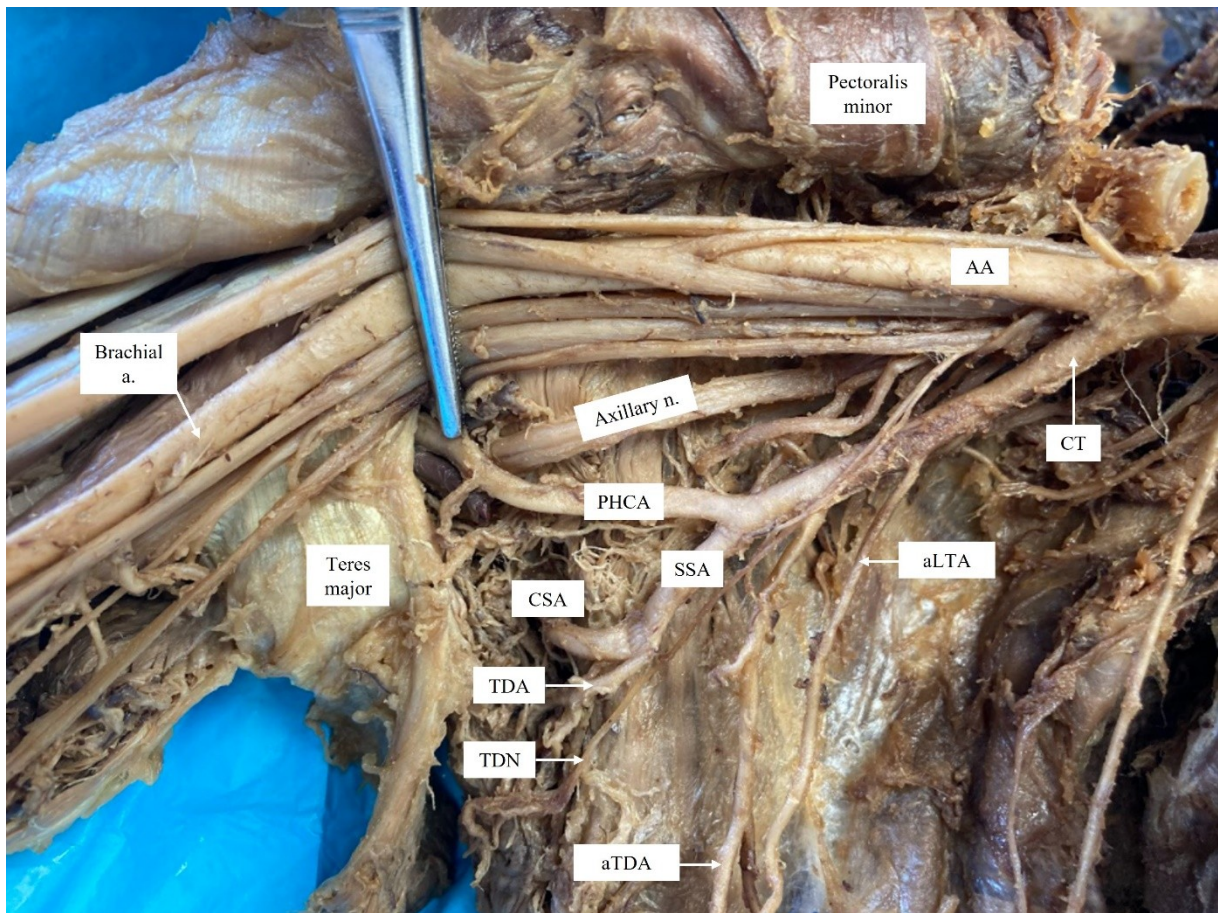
Common trunk from the first part of the AA. The CT provides the aLTA and aTDA before terminating as the SA (which bifurcates into the CSA and TDA) and the PHCA artery. The TDA travels with the TDN and the PHCA travels with the axillary nerve. The AA was observed continuing as the brachial artery distal to the teres major muscle. Abbreviations: AA (axillary artery), aLTA (accessory lateral thoracic artery), aTDA (accessory thoracodorsal artery), CSA (circumflex scapular artery), CT (common trunk), PHCA (posterior humeral circumflex artery), SSA (subscapular artery), TDA (thoracodorsal artery), TDN (thoracodorsal nerve).
